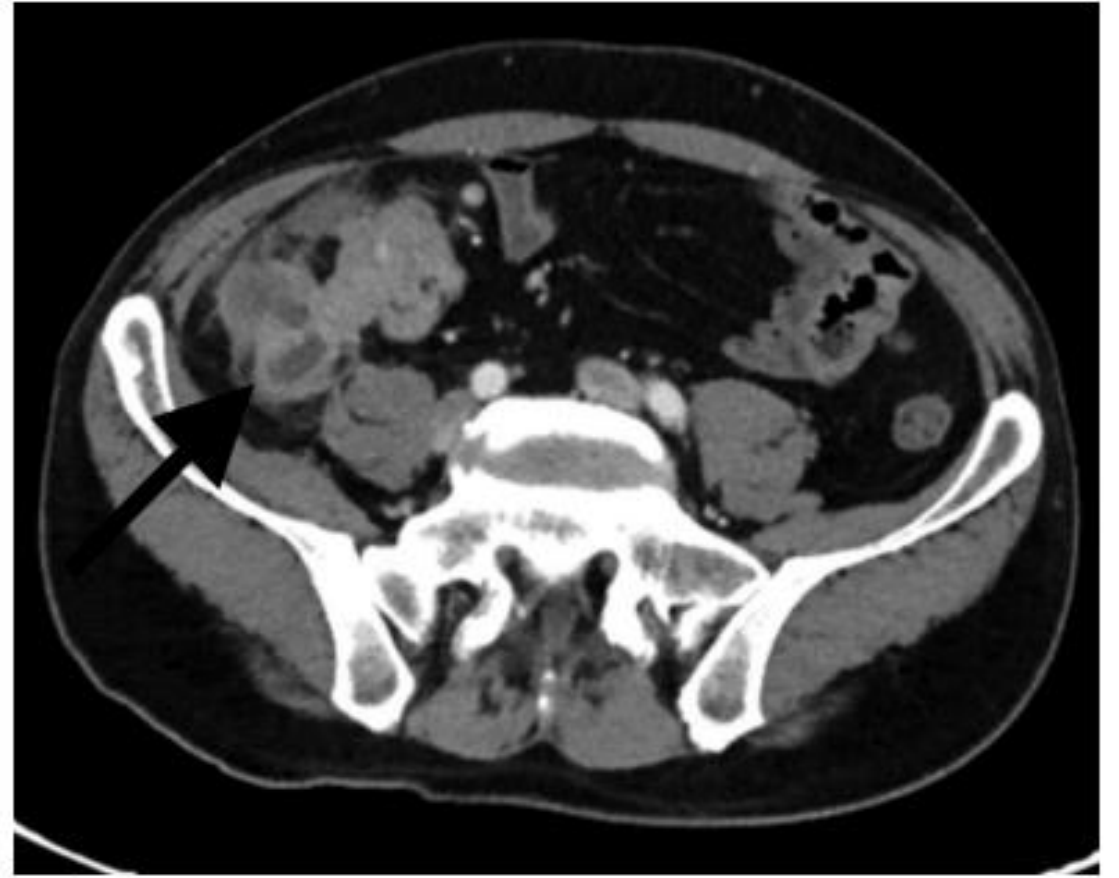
Computed tomography image showing appendiceal mass
